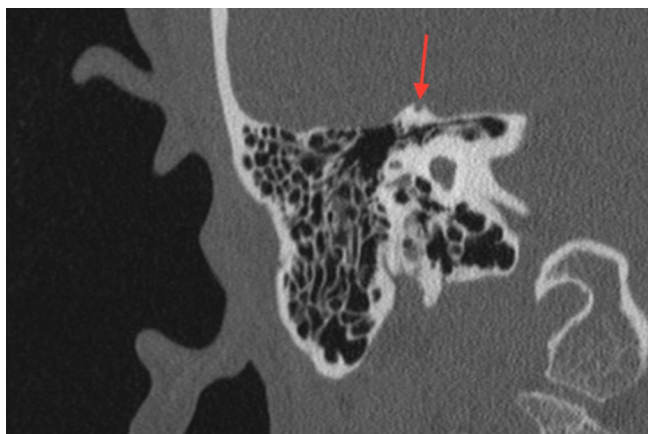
High-resolution computed tomography (HRCT) of the right temporal bone, indicating superior semicircular canal dehiscence via a coronal view. HRCTs are the gold standard for confirming diagnosis of SSCD. This coronal view of the right temporal bone shows the bone dehiscence, as indicated by the red arrow; this dehiscence is the abnormal “third mobile window” that can cause a variety of vestibular and auditory symptoms.
